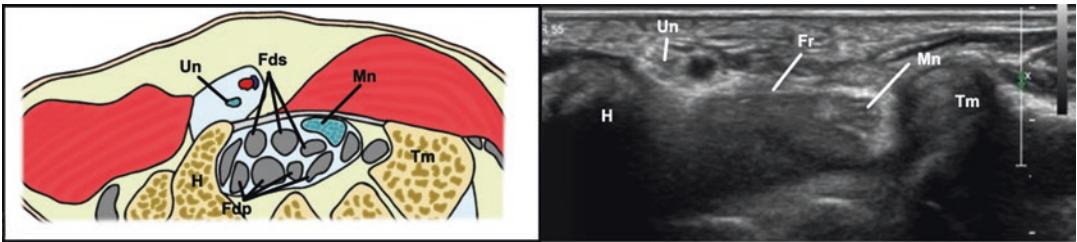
Axial ultrasound image—normal anatomy at the hamate hook; *Tm* trapezium, *Td* trapezoid, *C* capitate, *H* hamate, *Mn* median nerve, *Un* ulnar nerve, *Fdp* flexor digitorum profundus, *Fds* flexor digitorum superficialis, *Fpl* flexor pollicis longus, *Fcr* flexor carpi radialis, *Fcu* flexor carpi ulnaris, *Fr* flexor retinaculum
